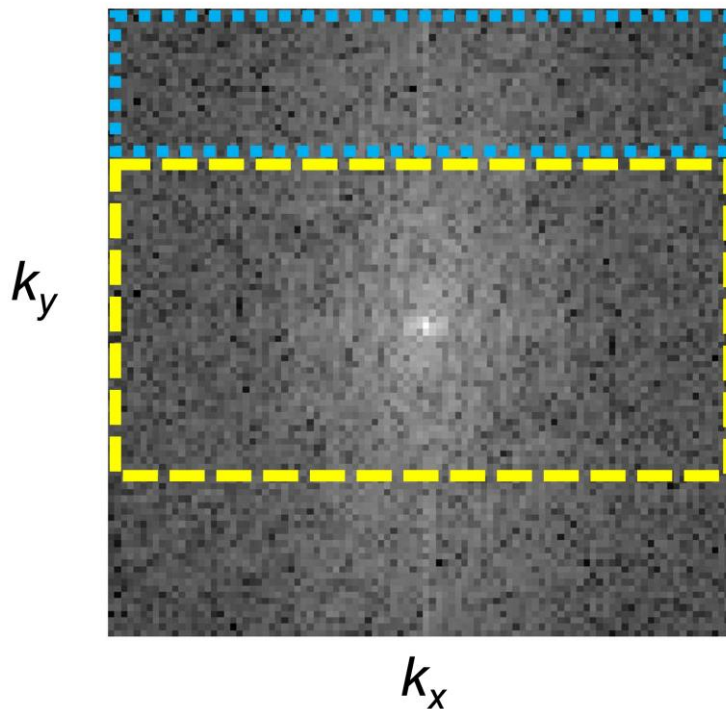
Figure B-0-2. Example k-space signal magnitude [A.U.] for a single diffusion-weighted MRI slice. The blue dotted outline highlights the region that would be asymmetrically sampled if 6/8 partial Fourier is used, while the yellow dashed outline highlights the symmetrically sampled region. Data below the yellow dashed region would be estimated by assuming conjugate symmetry with the blue dotted region while simultaneously incorporating phase error corrections derived from the yellow dashed region.
